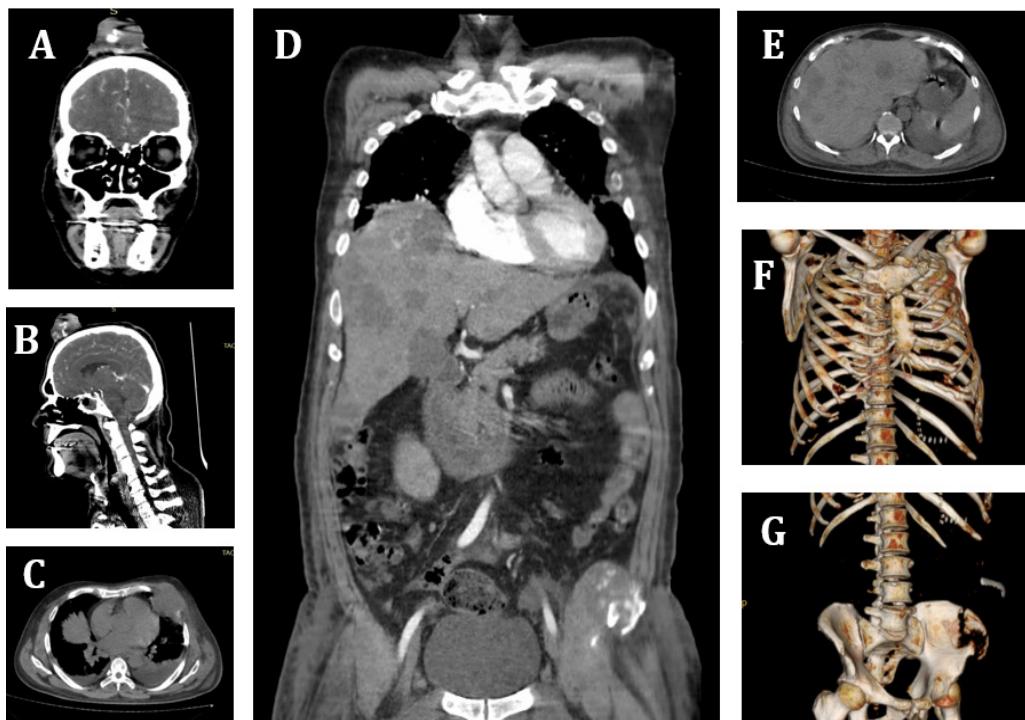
Cephalocaudal computed tomography. Brain, coronal (A) and sagittal (B) sections show frontal and parietal subcutaneous masses, multiple homogeneously enhancing cerebral and cerebellar metastases and perilesional finger-like edema. Thorax and abdomen coronal (C, E) sections show multiple hypoenhancing liver masses with peripheral enhancement, solid right renal lesion measuring 7.3×6.2 cm, extensive lytic bone metastases with pathological fracture of T4. sagittal (D) section shows multiple diffuse solid nodular metastatic lesions in bilateral lung parenchyma, bilateral pleural effusion, primary mass measuring 6.5×6.2 cm in the left 4th intercostal space with extension to the pectoral muscles. Bone reconstruction (F, G) shows extensive lytic bone metastases with pathological fracture of T4 and left iliac crest.
